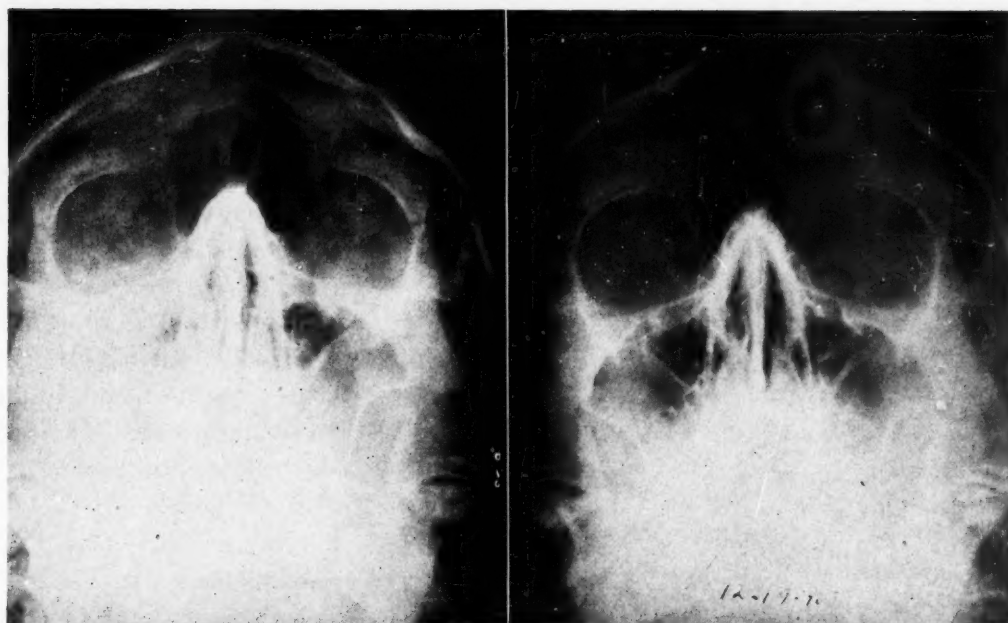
X-rays of sinuses before treatment (left) and after treatment (right), revealing moderate antral clearing with some residual thickening of the lining membrane.
